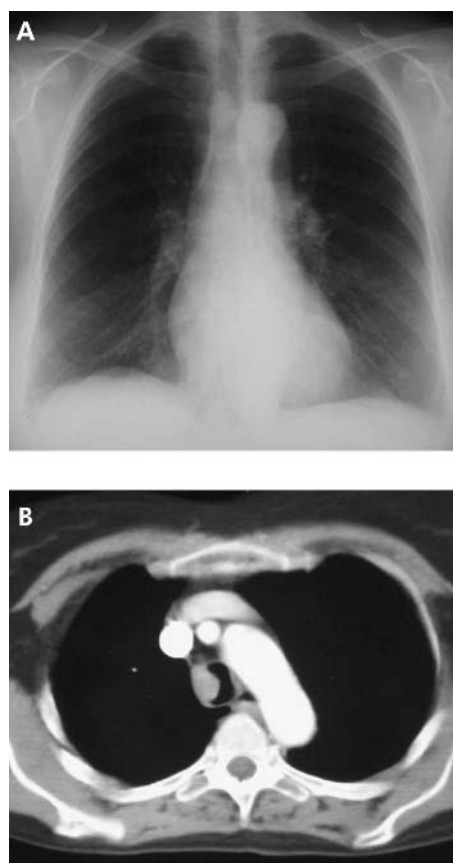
(A) Chest radiograph and (B) CT scan showing mid tracheal tumour.
